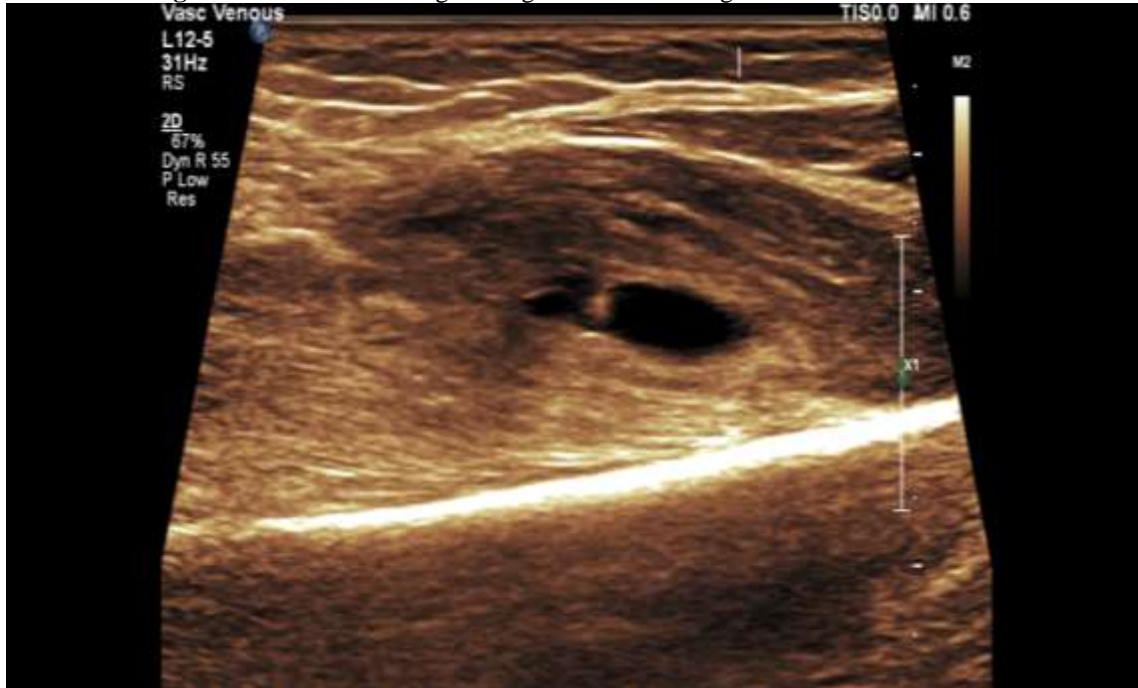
Ultrasound Image of Right Elbow Showing Scolex.
